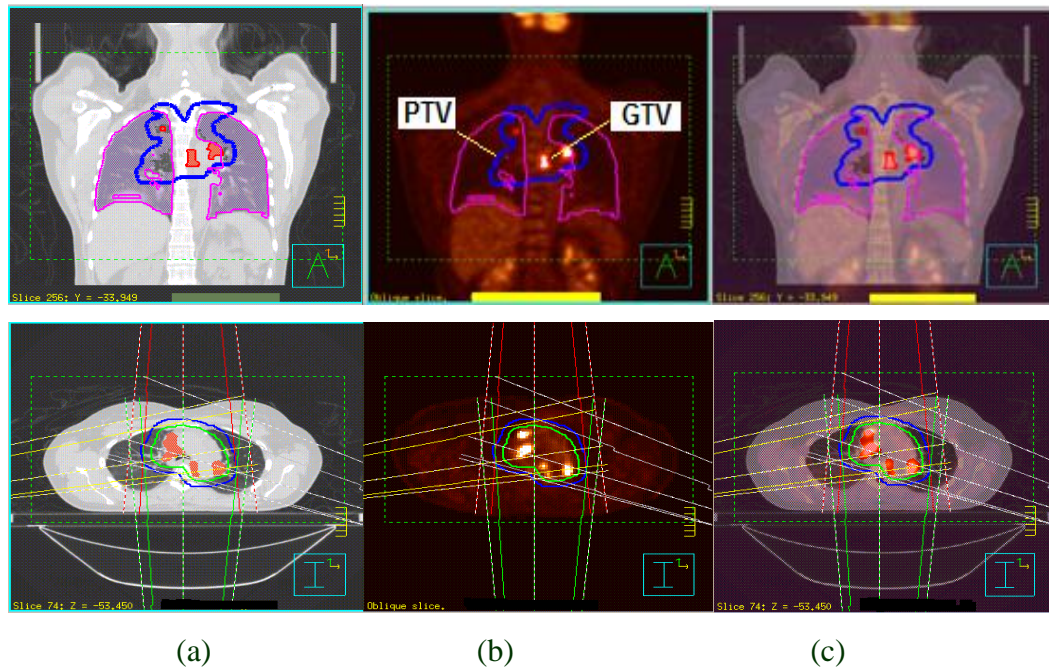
Three dimensional conformal radiation therapy (3DCRT) treatment of the left-lung cancer patient using the (a) computed tomography (CT) scan, (b) positron emission tomography (PET) scan, and (c) manual PET/CT image fusion.
